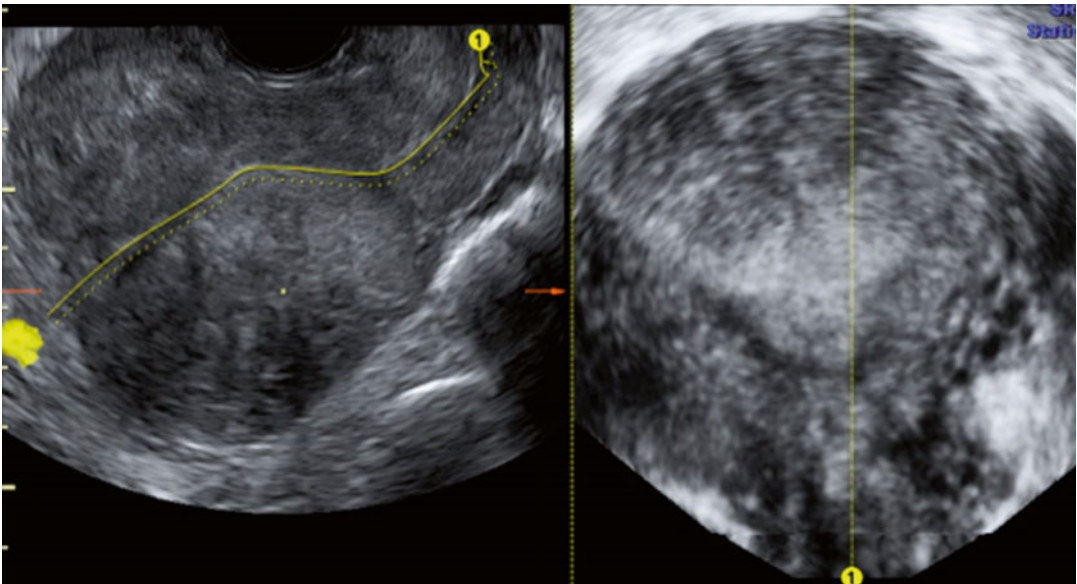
Ultrasound image of the uterus with adenomyosis. On the *left*, a longitudinal section of a globular enlarged uterus with asymmetrically thickened of the uterine wall and with diffuse inhomogeneous, irregular myometrial echotexture and presence of hyperechoic
